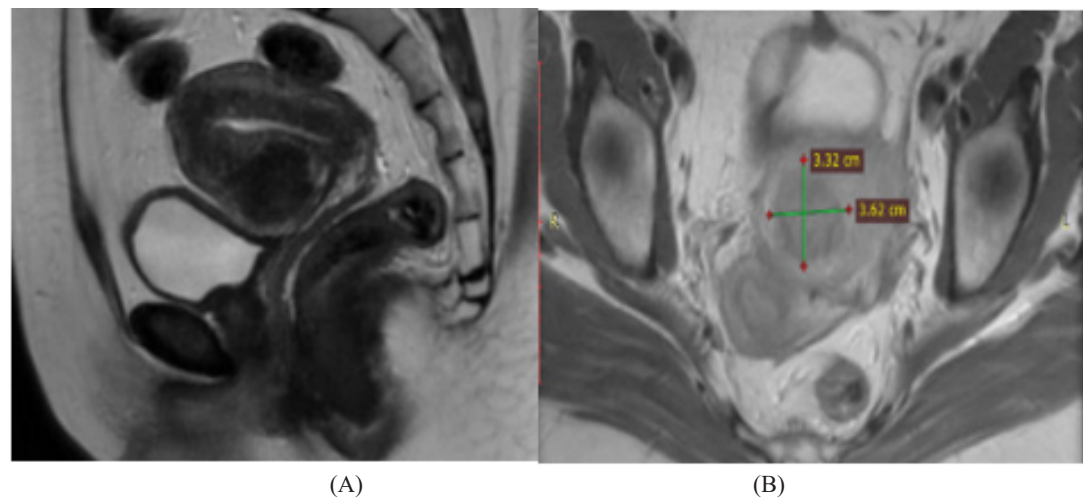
Post MR-HIFU for patient in figure 5. Sagittal (A) & Axial (B) post-contrast T1 MRI images revealed areas of non-enhancement within the former myoma denoting well ablation. Volume of ablated areas after HIFU = 7 cc, calculated NPV = 53%
